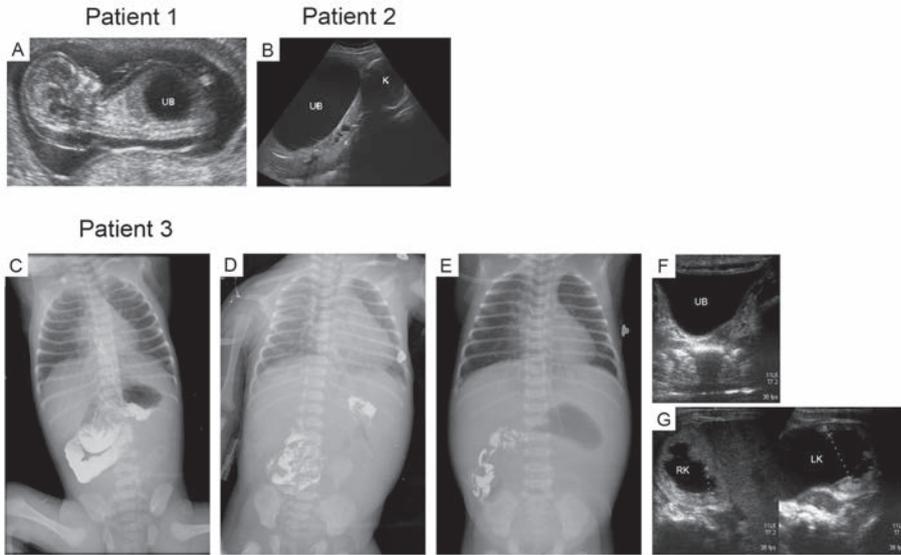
Barium enema and ultrasonography examinations in the three MMIHS patients. (A) Prenatal ultrasonography on patient 2 at 13 weeks revealed distended bladder and generalized subcutaneous edema. (B) Prenatal ultrasonography on patient 3 at 24 weeks revealed distended bladder, hydronephrosis and severe oligohydramnios. (C-E) Barium enema testing suggested intestinal obstruction and malrotation. (F and G) Ultrasonography on patient 1 at neonatal revealed dilatation of the bladder and bilateral hydronephrosis. Legends: K: kidney, UB: urinary bladder.
